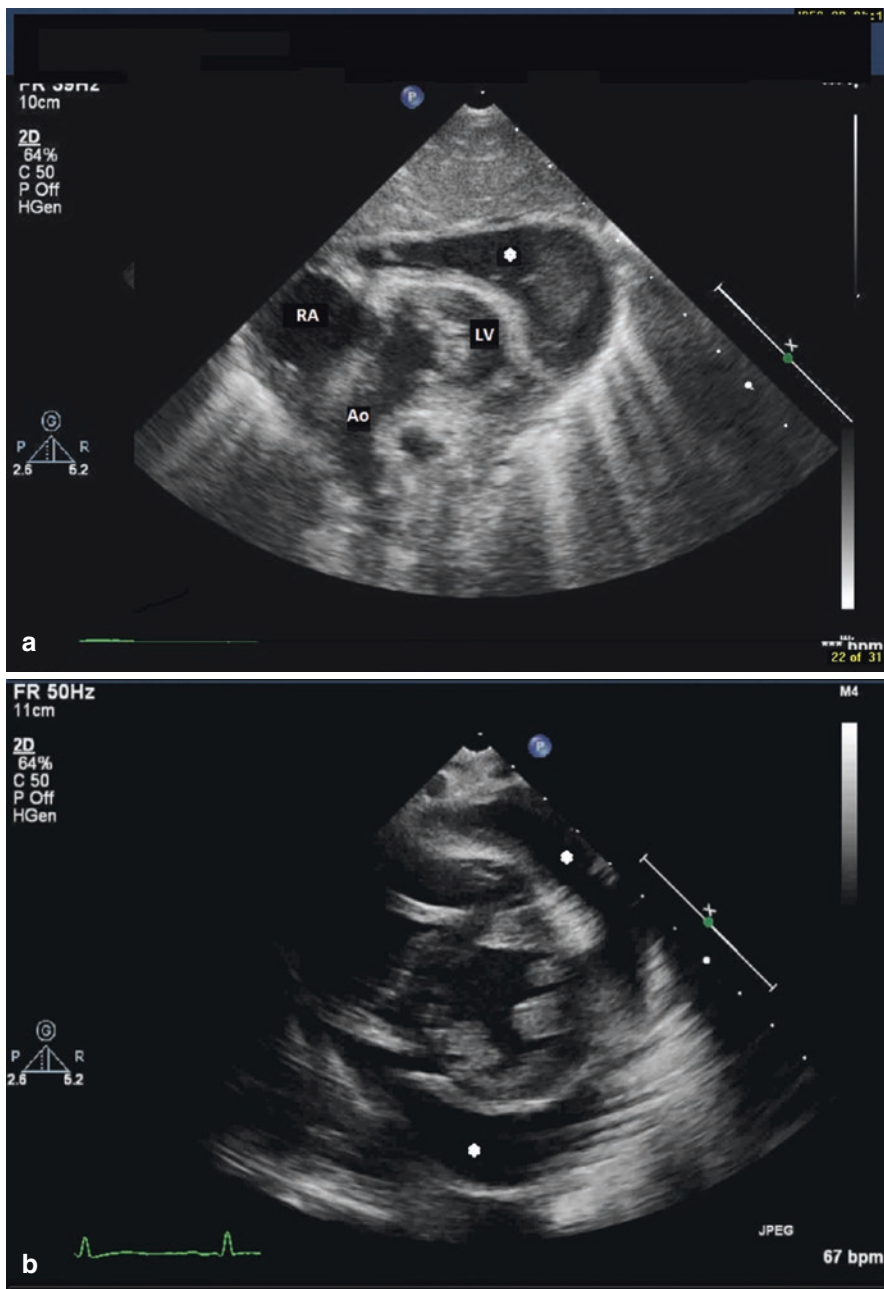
A large pericardial effusion (asterisk) as seen from (a) the subxiphoid view and (b) the parasternal short-axis view. The echogenic area in the pericardial space is fibrinous material, as seen in the subxiphoid view
